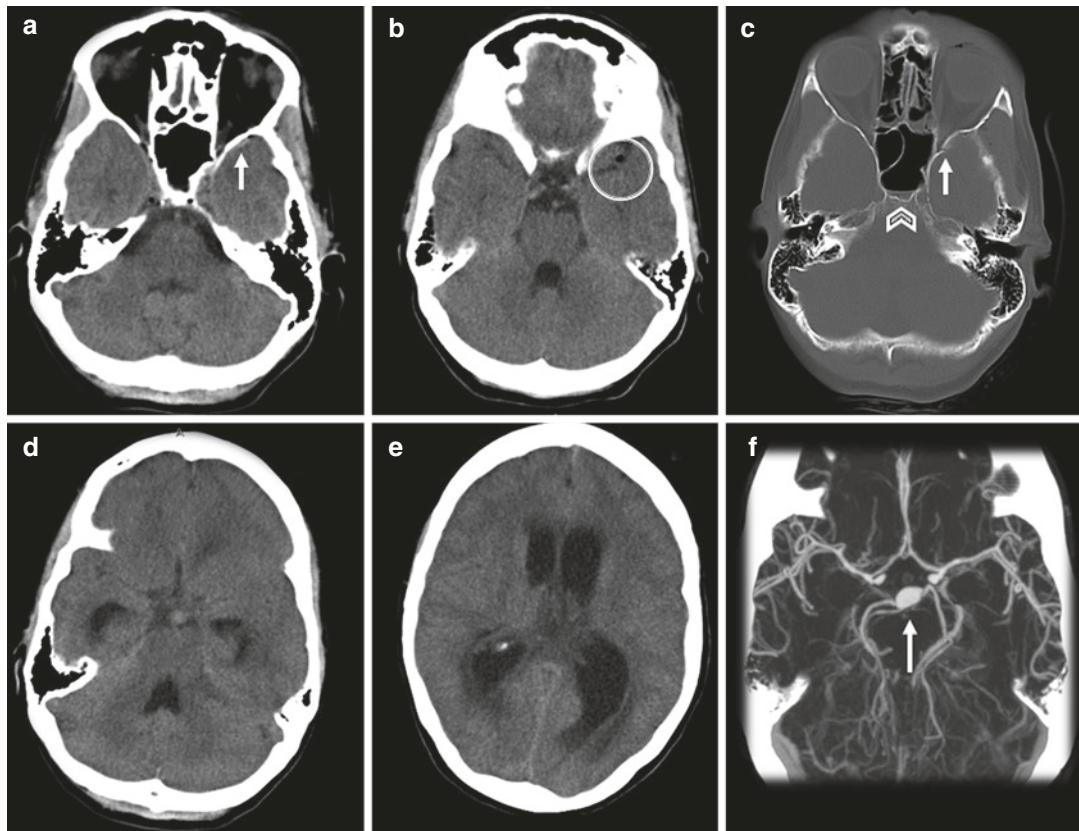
Patient with head trauma, involved in a motor vehicle collision. Initial head CT was reported as normal; however, several subtle but important findings including a small subdural hematoma (SDH) in the anterior aspect of the left middle cranial fossa (arrow in a), minimal pneumocephalus within the left sylvian fissure (circle in b), a linear fracture of the lesser wing of the left sphenoid bone (arrow in c), and an air-fluid level within the sphenoid sinus (chevron in c) were all initially missed prospectively. The patient returned to the hospital 2 weeks later with intractable headache, fever, and neck rigidity, suggestive of meningitis. The head CT at that point showed marked communicating hydrocephalus secondary to meningitis (d, e) in the context of a missed skull base fracture. Additionally, there was an infectious basilar artery pseudoaneurysm (arrow in f), as seen on the axial CT angiogram image of the head (f)
